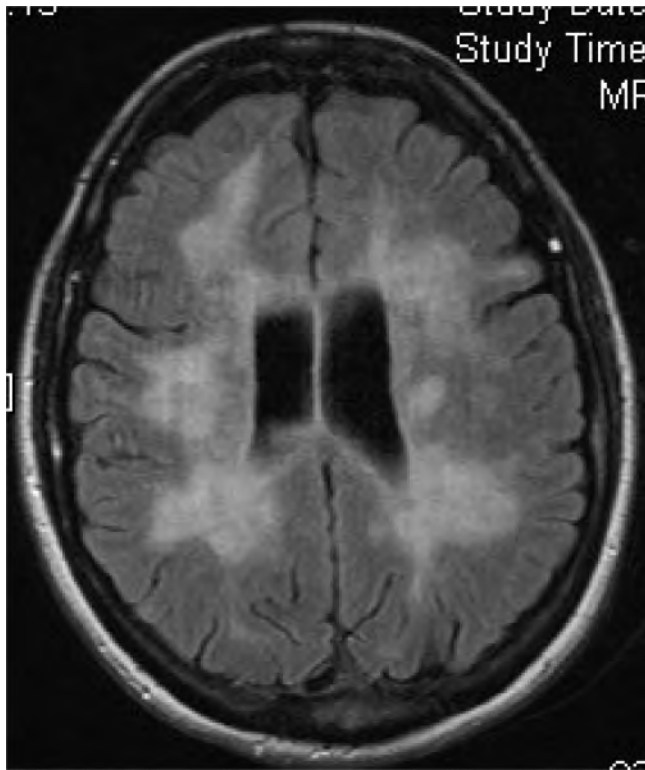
Marburg variant of multiple sclerosis (MRI T1W axial).
